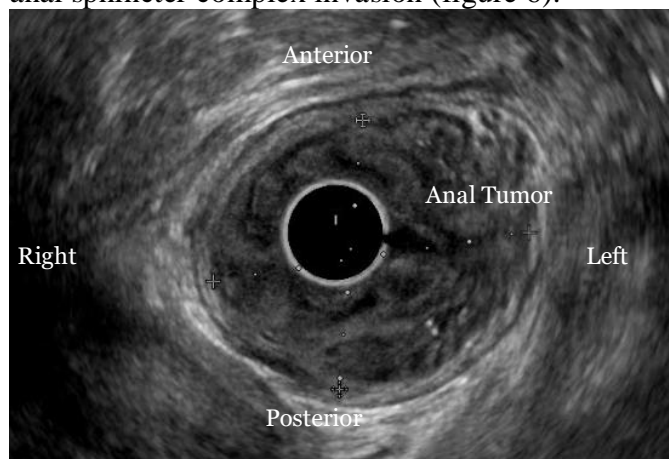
Endoanal ultrasound image showing an anal tumor measuring 39×31mm, invading the mucosae and submucosae
